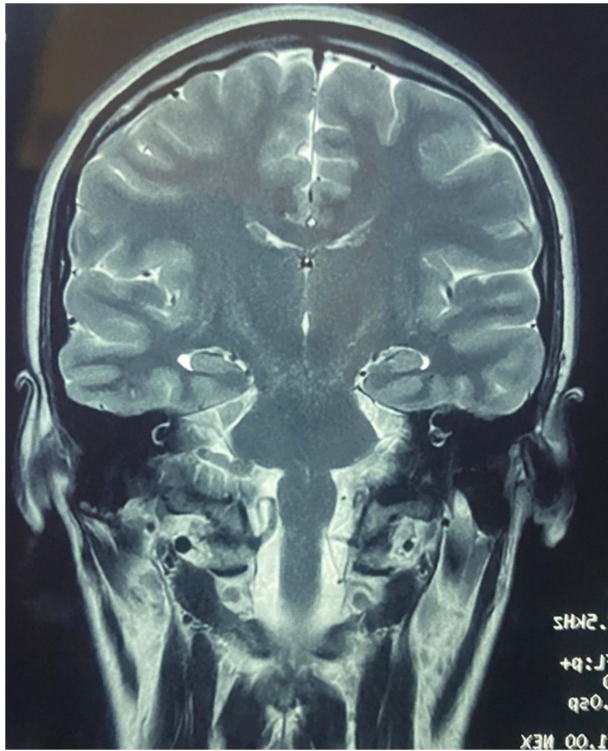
Coronal section of brain magnetic resonance imaging showing evidence of compressing vascular loop.
